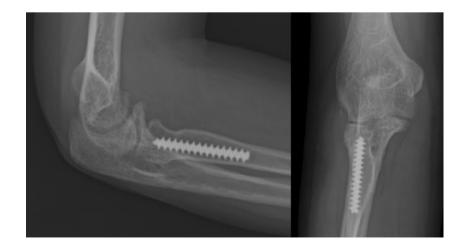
Anteroposterior and lateral radiographs of the elbow of case III. Plain radiographs revealed fibrous union at the autograft-host junction with a hypertrophic callus and a radiolucent halo around the metal screw
